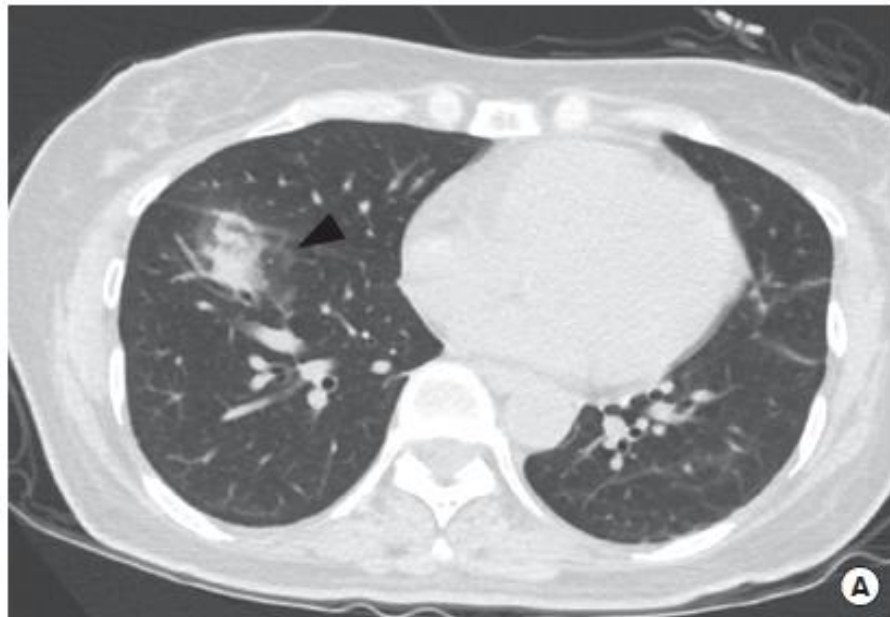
Evolution of computed tomography (CT) findings in pulmonary mucormycosis in a 50-year-old woman with acute myelogenous leukemia. (A) Lung window image of CT scan (2.5-mm-section thickness) demonstrates ill-defined focal consolidation with ground-glass halo (arrowhead) in right lower lobe. (B) Lung window image of CT scan (2.5-mm-section thickness) obtained 3 weeks later shows progression of right lower lobe consolidation extending to right middle lobe. Note central low-attenuation area (arrowhead) within the dense consolidation representing ischemic change. (C) Mediastinal window image of CT scan (2.5-mm-section thickness) obtained 1 week after (B) shows large area of central necrotic area (arrowhead) within the dense consolidation.
